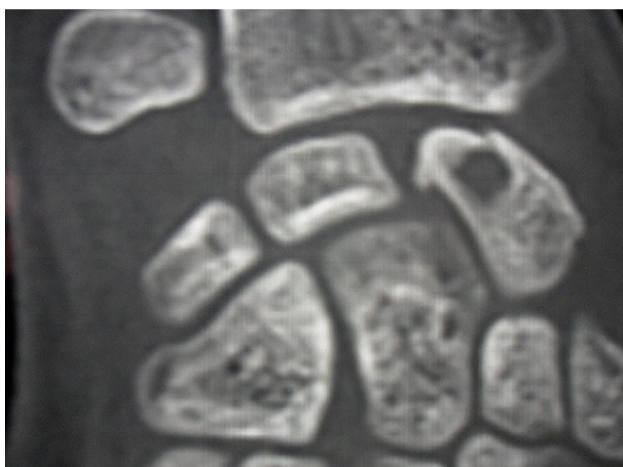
Coronal CT-scan confirmed a cystic lesion of the scaphoid and was able to localize the lesion and the fracture precisely. Other carpal bones and adjacent joints were normal
